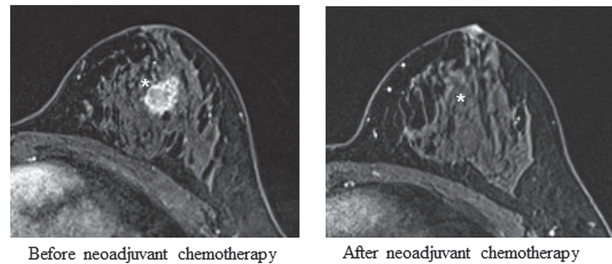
Contrast-enhanced MRI, allowing more detailed information for making the diagnosis of breast cancer, showed a 21-mm mass in the right breast with rim enhancement (left). In the right MRI, there was no sign of breast cancer after neoadjuvant chemotherapy, suggesting a clinical complete response.
